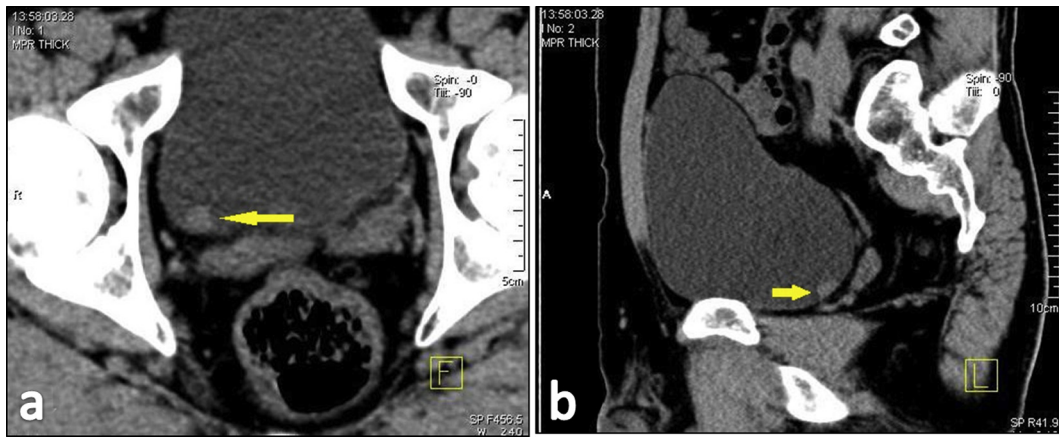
Forty-three year old male patient with left flank pain. CT stone protocol through the urinary bladder in axial (a) and sagittal (b) planes shows small mass lesion in right postero-lateral wall (arrows), turned out by cystoscopy to be a small urothelial tumor.
